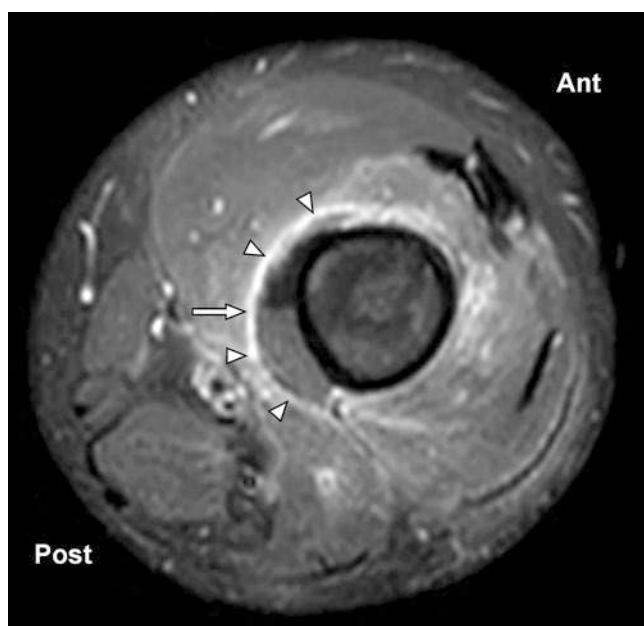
Three year-old boy with methicillin resistant staph aureus (MRSA) osteomyelitis. The patient presented with arm swelling, pain and fever. MRSA was found on blood culture prior to imaging. (a) Anteroposterior radiograph shows a subtle lucency within the proximal humeral metaphysis (*arrow*). At most, there is subtle abnormality of diaphyseal bone. Soft tissue swelling is most prominent medially, near the elbow (*arrowheads*). (b) Fat-saturated sagittal T1-weighted MR image after gadolinium-based
